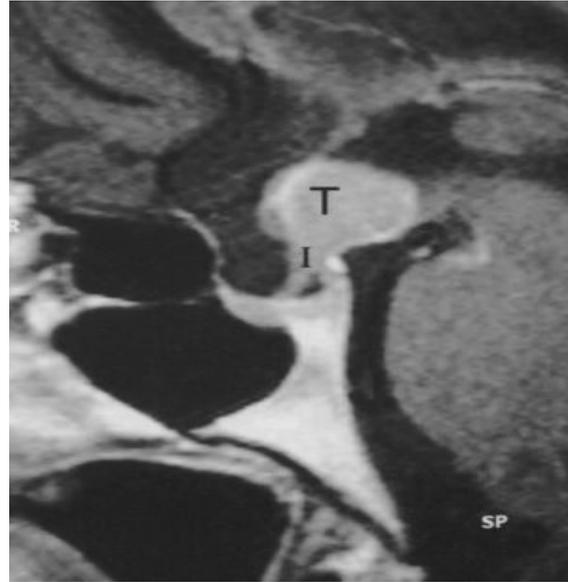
Sagittal MRI, T1 sequence with intravenous contrasted agent showing enhancing mass (T) in the floor of third ventricle extending to pituitary infundibulum (I) and optic chiasm.
